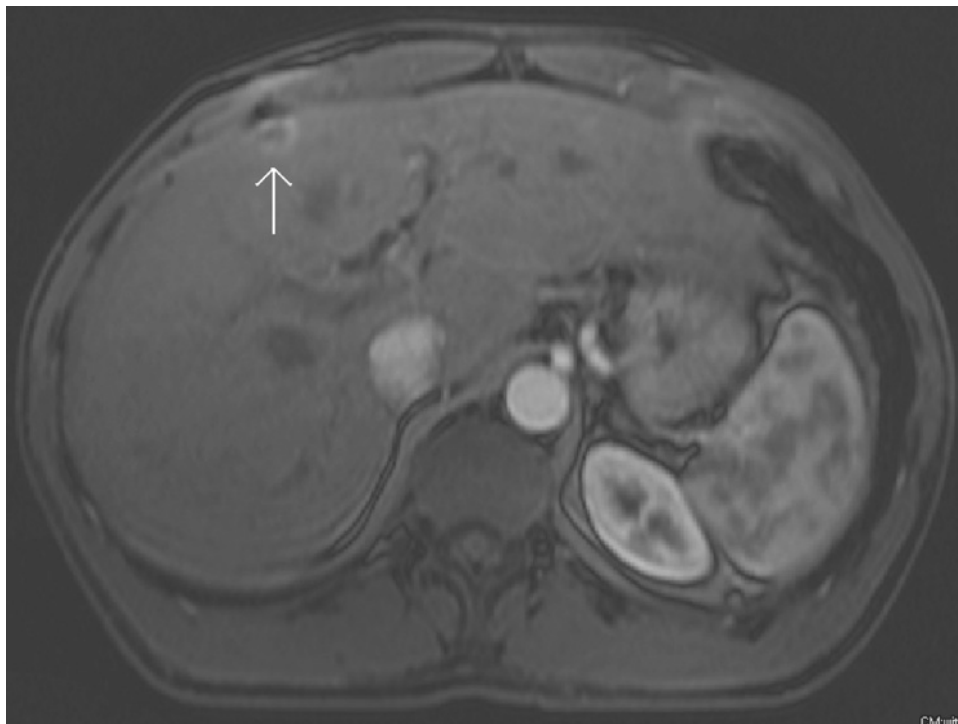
T₂ axial MRI image of 1.2- × 1.3-cm mass in medial segment of the left liver lobe.
